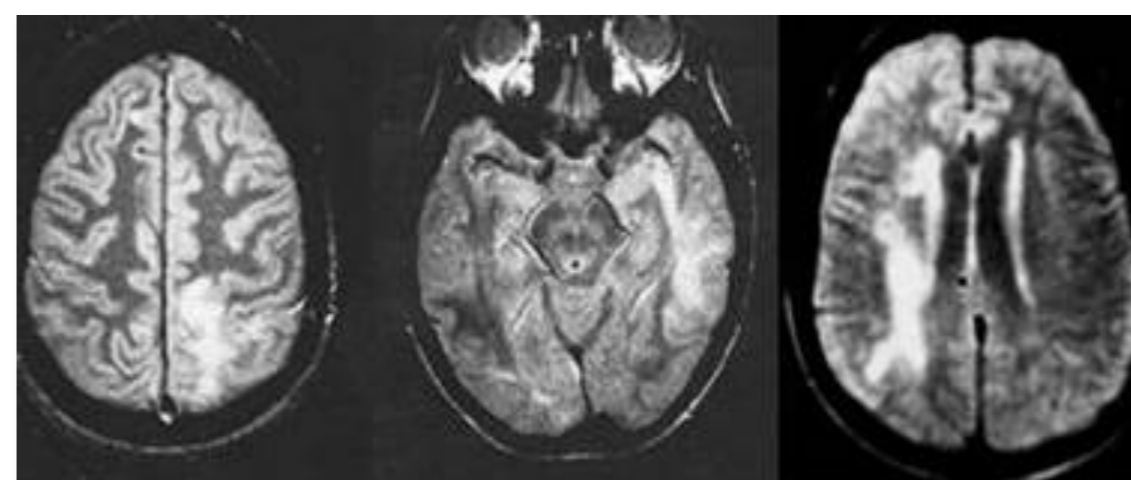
Magnetic Resonance imaging in PML
